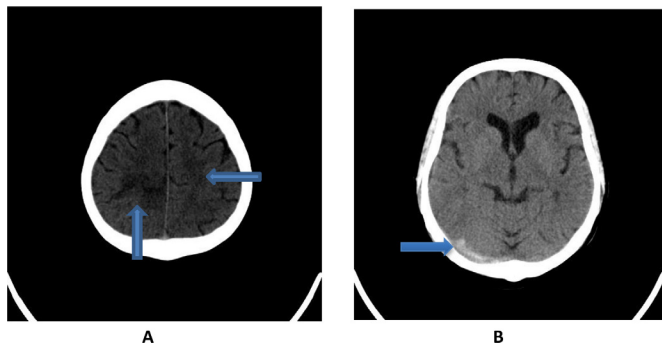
Plain CT brain images. (A) Low density seen within the right parietal lobe with further patchy low density within the posterior aspect of the left parietal lobe suspicious for recent infarct. (B) Hyperdensity of right transverse sinus suspicious of thrombus (this non-contrasted CT finding may be misinterpreted as haemorrhage).
